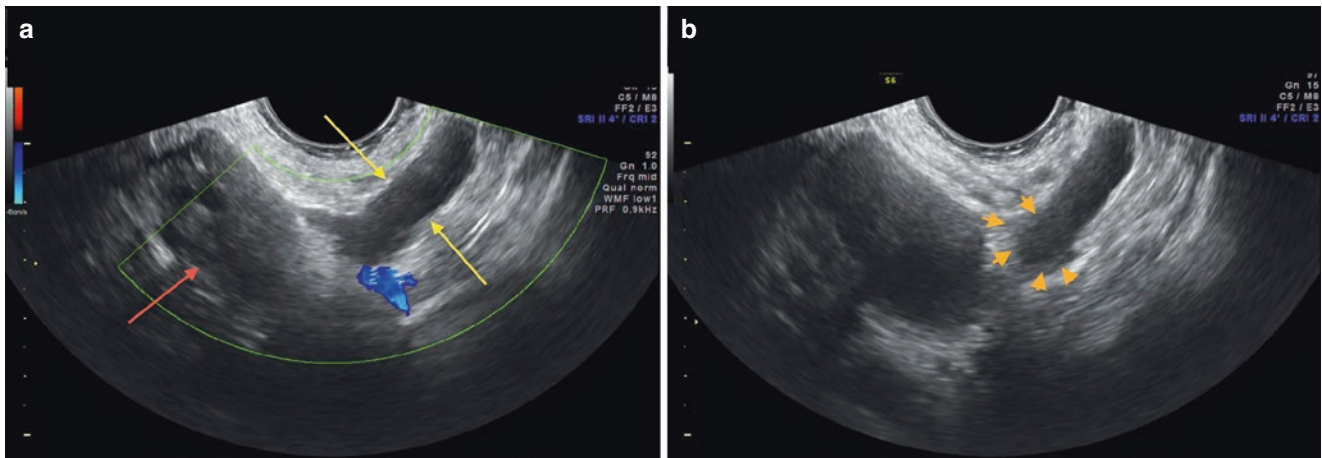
Salpingitis to the left: (a) Endovaginal ultrasound, showing left tube (yellow arrows) as a tubular structure with thick liquid content, adjacent to the left ovary (red arrow). In (b) we can note the irregularity
